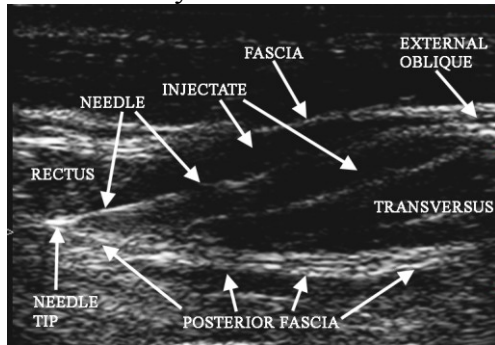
Sonogram of lateral rectus abdominis block
